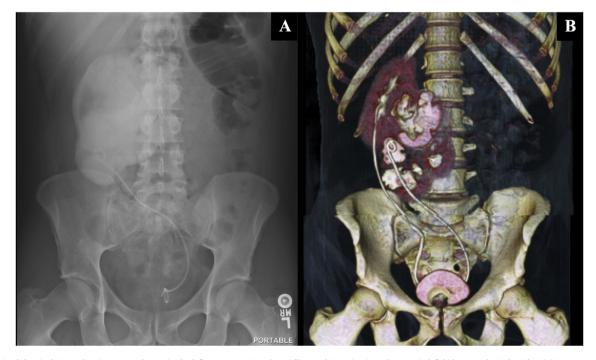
A) Plain abdominal X-ray showing ureteral stent in the left ureter crossing the midline and inserting into the ectopic left kidney on the right side; B) 3-D reconstruction of the computed tomography scan showing crossed fused renal ectopia with inferior fusion.
